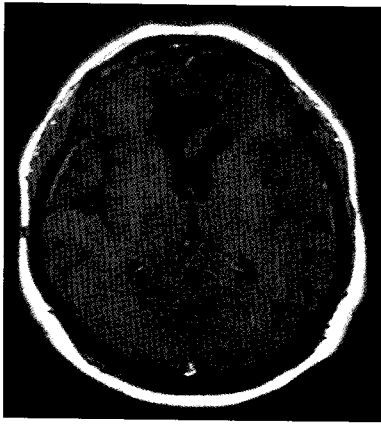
Magnetic resonance FLAIR imaging shows peritumoral and pericystic edema.
